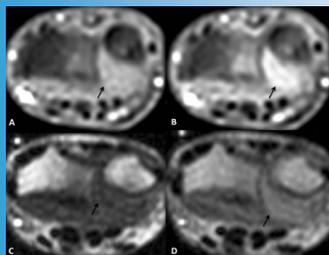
(A, B) Axial T1-weighted fat-saturated image of the wrist following a DCE MRI dynamic study on a 3.0T MRI machine at early (A) and late (B) dynamic phases. There is an increase in enhancement at the distal radioulnar articulation (arrow). (C, D) Axial T1-weighted image of the wrist of the same patient following a DCE MRI dynamic study on a 0.25T MRI machine at early (C) and late (D) dynamic phases. There is an increase in enhancement at the distal radioulnar articulation (arrow). The area of synovial enhancement is similar between 0.25 and 3.0T.
